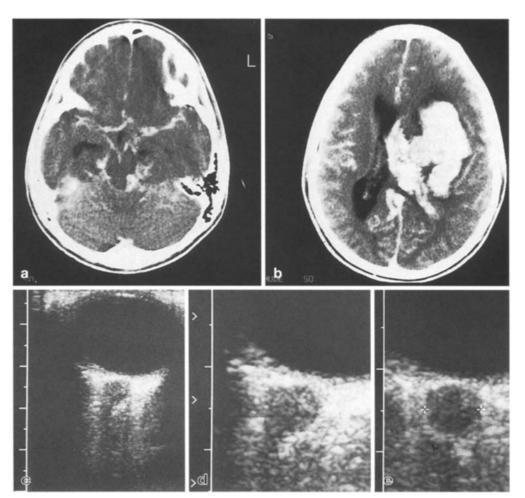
A 13-year-old boy with large intracerebral hemorrhage after angioma resection. Cranial computed tomography (CCT) and orbital sonography were performed on the same day. a,b CCT. Hemorrhage involves the parenchyma and the subarachnoidal space. There is a midline shift and general cerebral edema. c-e Orbital sonography. c An overview shows the dilated optic nerve (echolucent rim) in transverse section. d, e Details of the optic nerve entry zone are shown. Both optic nerve sheath diameters (ONSD) are clearly enlarged (d 6.0 mm; e 6.2 mm)
